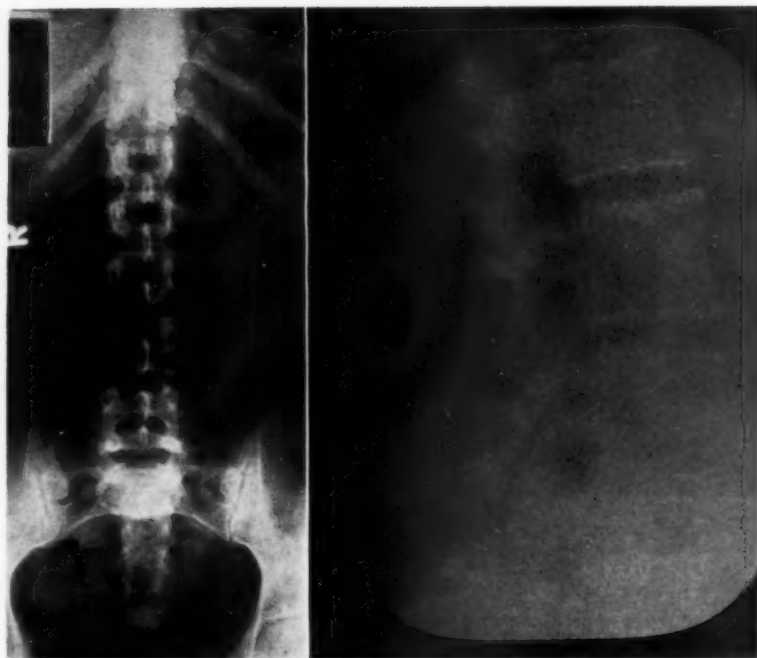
Anteroposterior and lateral films of the lumbar spine taken on April 10, 1954. There is complete destruction of the right lamina of L-2 with extension of this lesion into the base of the spinous process of L-2. This area filled in almost completely following deep x-ray therapy and did not recur.
